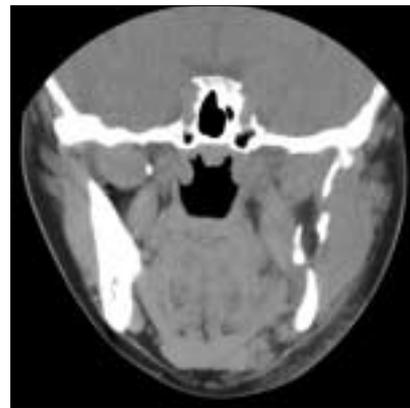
Coronal computed tomography scan showing an erosive lesion at the ramal area of the mandible.
